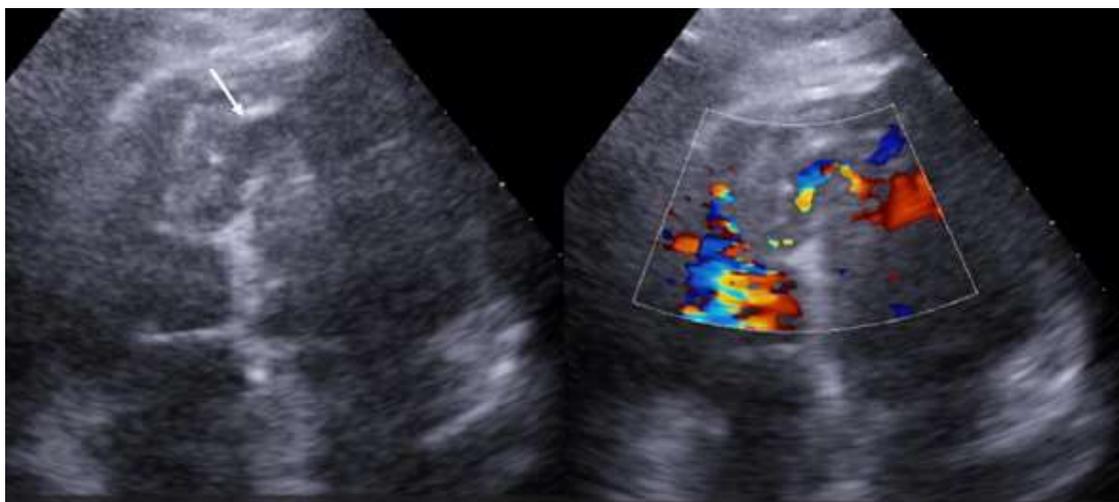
Transthoracic echocardiogram in apical four-chamber view showing disruption of the mid-apical interventricular septum (white arrow). Color Doppler demonstrates left-to-right flow from the left ventricle (LV) to the right ventricle (RV).
